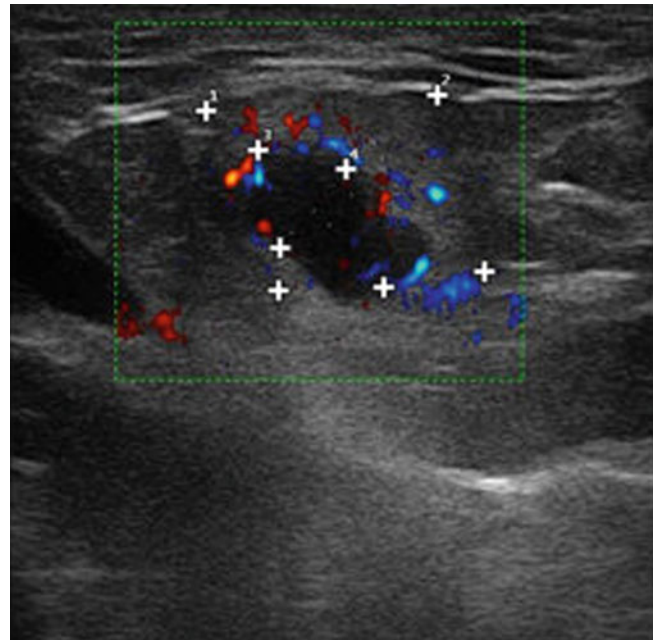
Metastatic lymph node. Directional power Doppler image. So-called echo-free Island
